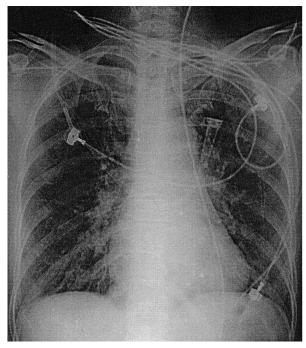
The chest radiograph taken after completion of the first course of HBO_2 therapy and removal of the endotracheal tube on the second day of admission shows minimal infiltrations in the right lower lung.
